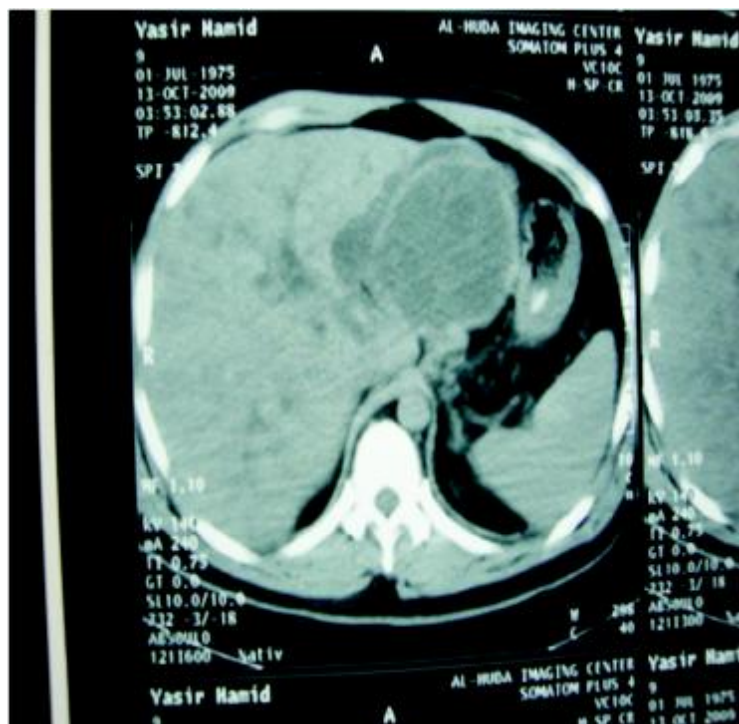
CT of liver with Left lobe hydatid cyst and left biliary
